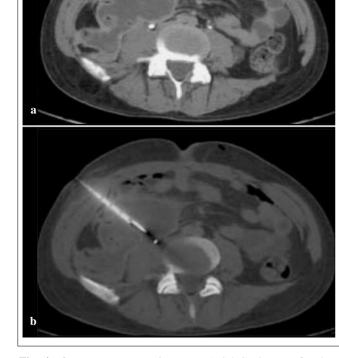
Axial CT image of a deep fluid collection drained with the "tandem" technique: a 20 gauge needle was advanced into the abscess cavity (*arrowhead*) as a guide for catheter insertion (*arrow*) in tandem with the needle (alongside the diagnostic needle
